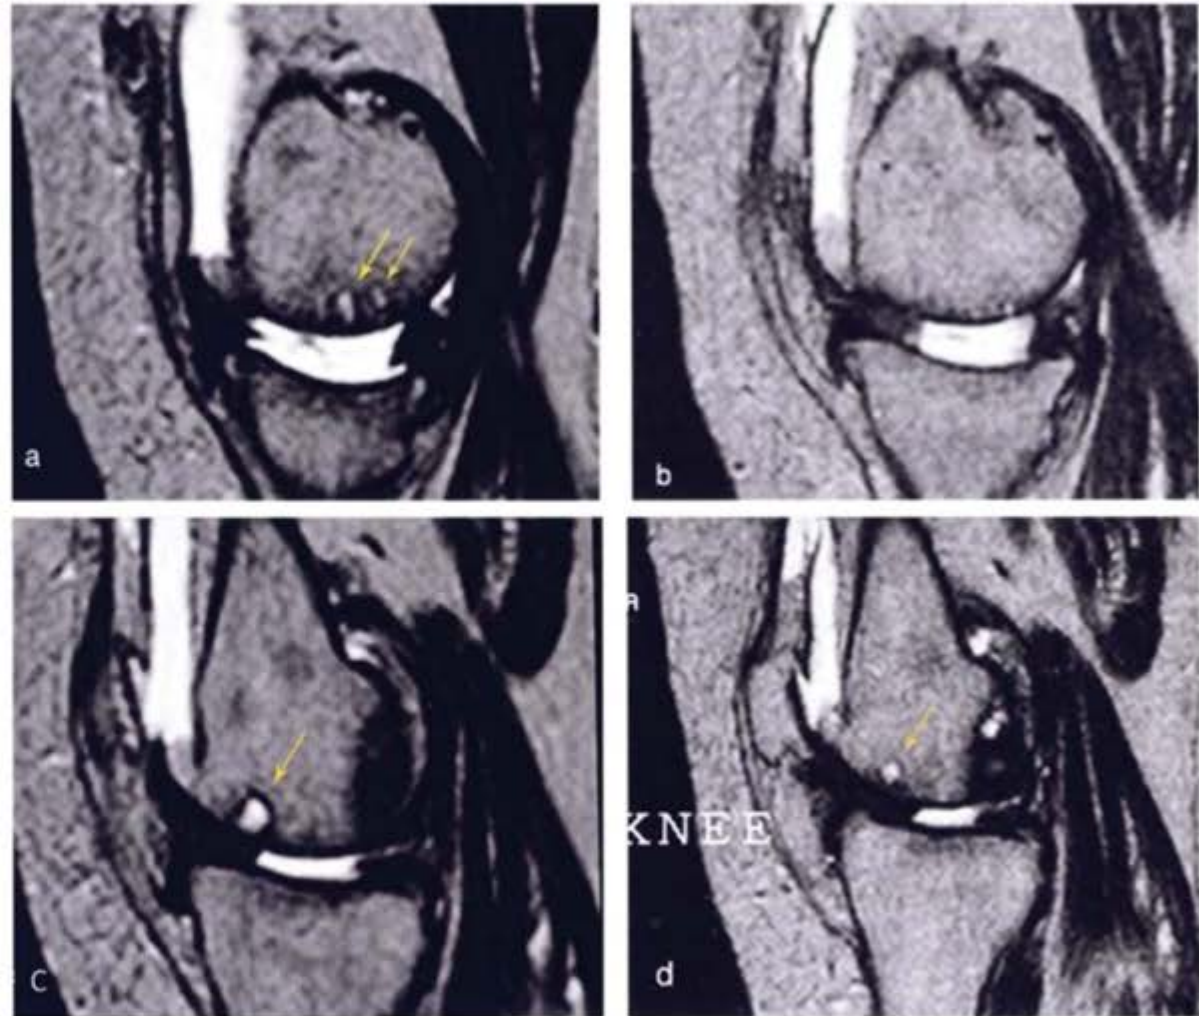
Sagittal MRI of the knee in a 65-year-old female patient with OA. Arrows in a and c show areas of increased signal intensity related to subchondral edema. Six months post-injection, MRI shows disappearance (b) or distinct decrease (d) of the size of these areas.
